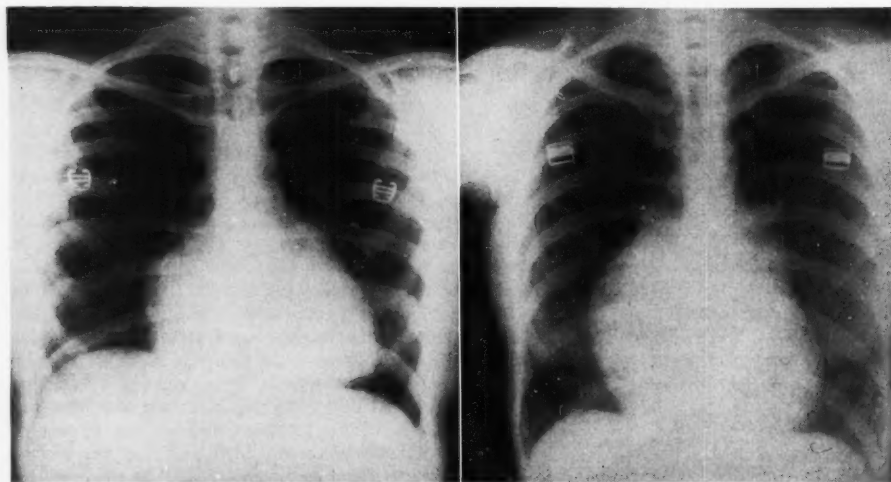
Roentgenograms of the chest of 2 patients with tricuspid stenosis, case 2 on the left and case 5 on the right.
